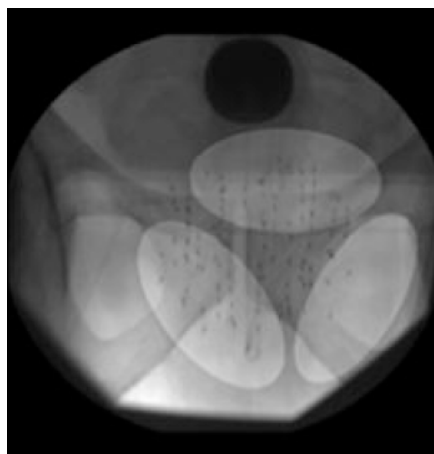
X-ray image which includes ellipse projections [ALD*10].
